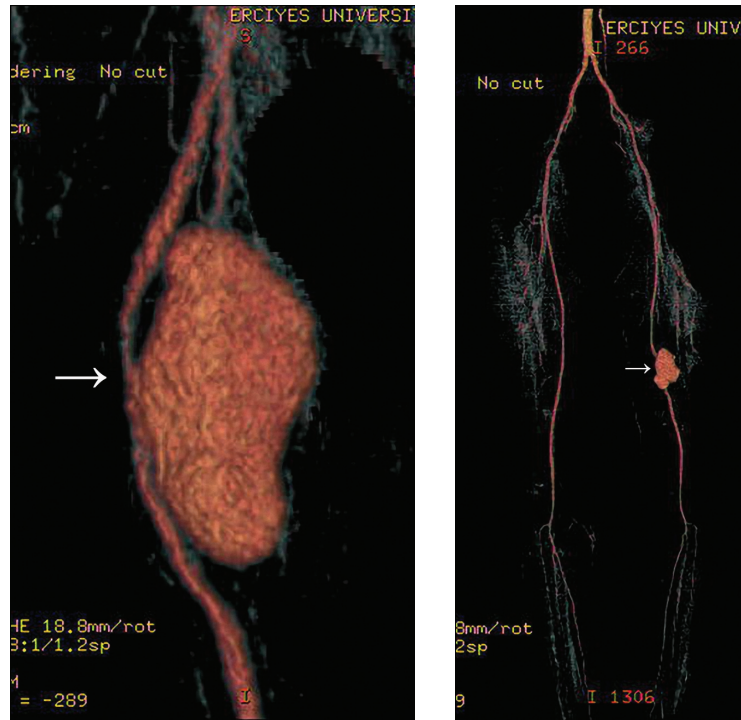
CTA shows a pseudoaneurysm (about 60 mm in diameter) that originates in the SFA (arrow).
